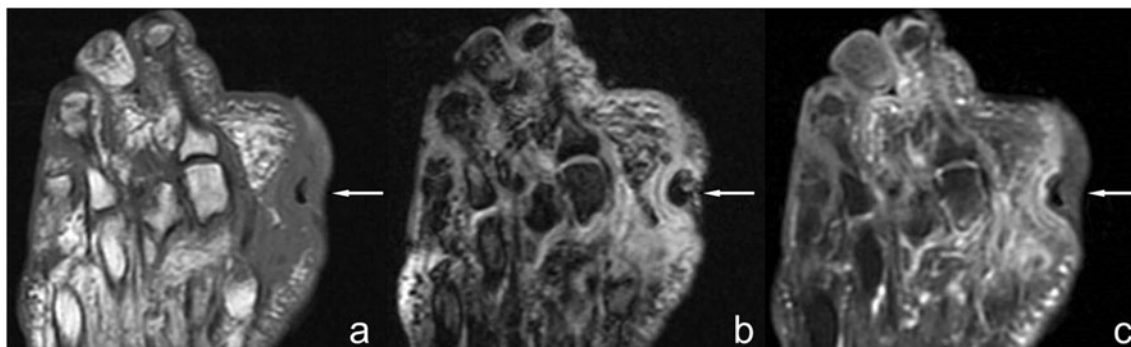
Skin ulcer in a 66-year-old diabetic woman. a) Axial T1-weighted, b) T2-weighted fat-suppressed, and c) post-contrast, T1-weighted, fat-suppressed MR images show a plantar ulcer (arrow in a–c) along the medial aspect of the first metatarsophalangeal joint. The ulcer is
